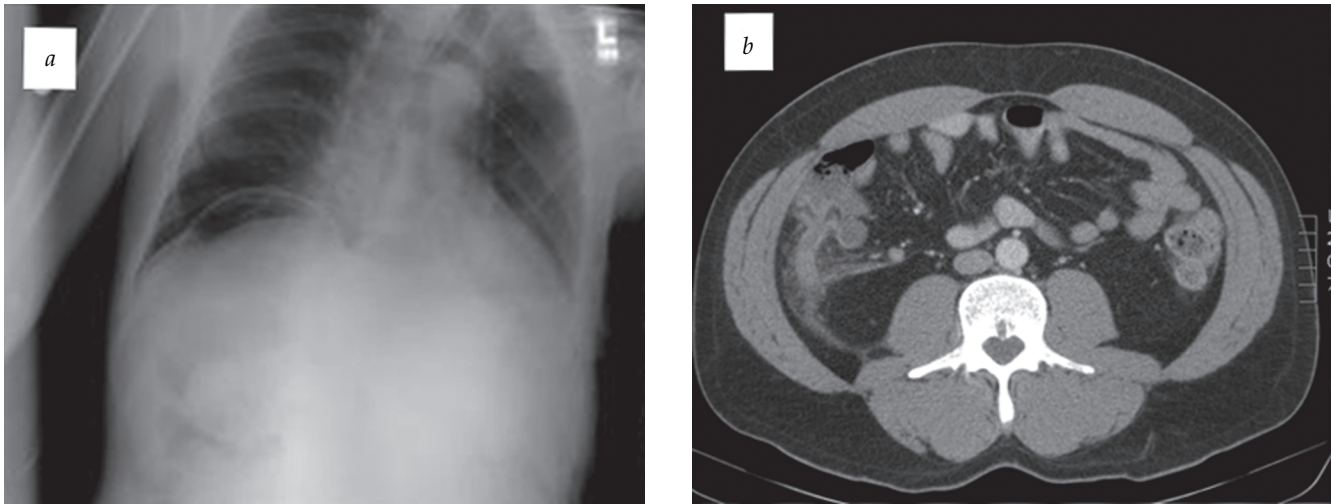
Representative radiologic findings that can result in bacterial peritonitis. (a) Free air can be evaluated by chest x-ray and found as pneumoperitoneum between the right hemidiaphragm and liver. (b) When the appendix is ruptured, appendicitis can lead to peritonitis.
